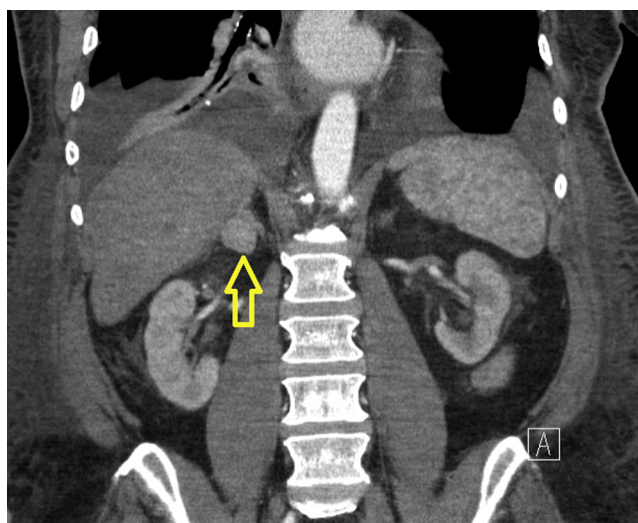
Coronal CT slice demonstrating bilateral adrenal nodules with the right nodule (arrow) measuring $2.2 \times 2.5 \times 2.4$ cm.
